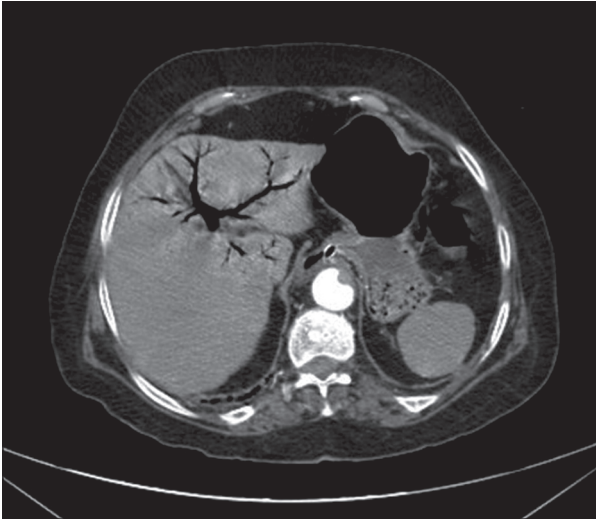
Axial CT scan of liver with iv contrast agent administered to 63-year-old female patient shows the presence of gas in intra-hepatic portal venous system.
